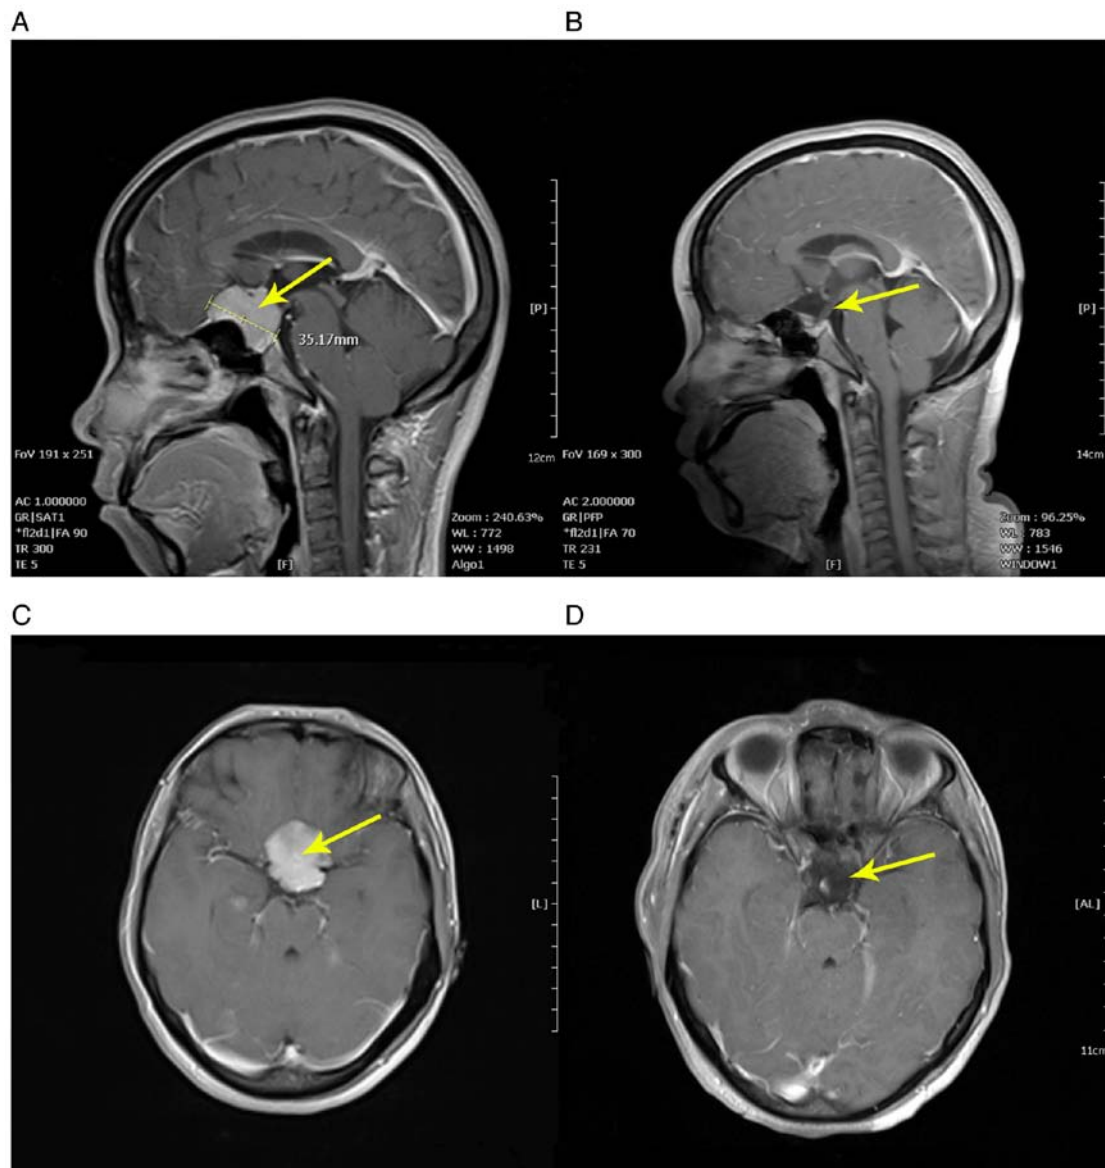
Case 1 of endoscopic supraorbital keyhole approach. Patient 3 is a 32-year-old female with decreased vision and headache. (A) Sagittal image of the preoperative MRI, showing an intrasellar tumorous lesion with a maximum diameter of 35.17 mm. (B) Sagittal image of the postoperative MRI, showing no remnant tumor tissue. (C) Axial image of the preoperative MRI. (D) Axial image of the postoperative MRI. The yellow arrow indicates the tumor or the tumor cavity.
